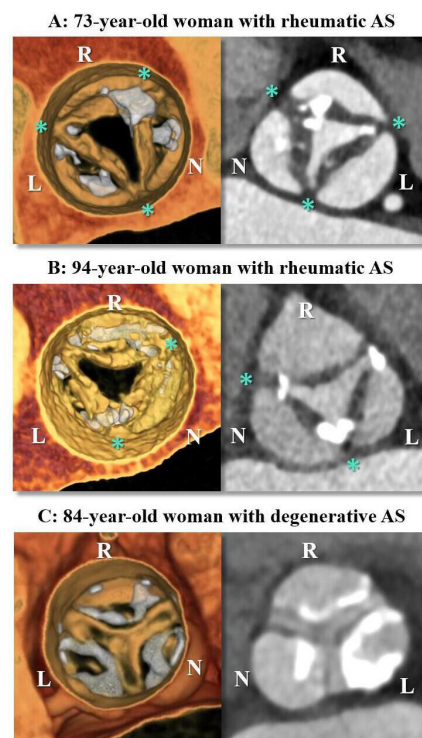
CT images in patients with rheumatic and degenerative AS (A) A central triangular-shaped systolic orifice, thickened leaflets, commissural fusion with calcification in rheumatic AS in a 73-year-old woman. (B) A central triangular-shaped systolic orifice, thickened leaflets, commissural fusion with calcification and slightly more diffuse basal calcification in degenerative calcified rheumatic AS in a 94-year-old woman. (C) A stellate-shaped orifice (no commissural fusion) with severe basal calcification shown in degenerative AS in an 84-year-old woman. commissural fusion. AS, aortic stenosis.
